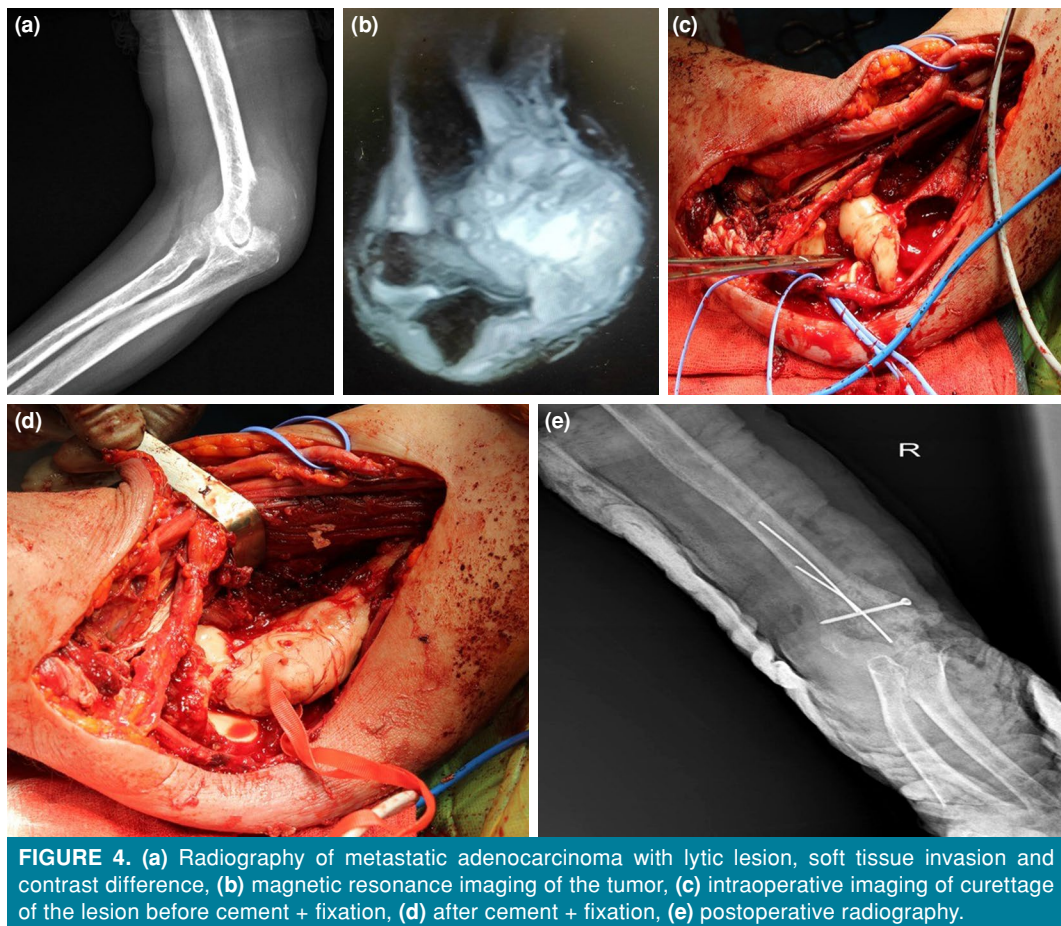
(a) Radiography of metastatic adenocarcinoma with lytic lesion, soft tissue invasion and contrast difference, (b) magnetic resonance imaging of the tumor, (c) intraoperative imaging of curettage of the lesion before cement + fixation, (d) after cement + fixation, (e) postoperative radiography.
